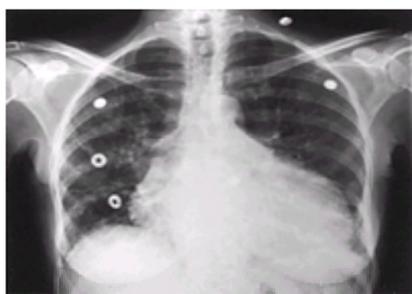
Chest roentgenogram demonstrates a large pericardial effusion, blunting of the left costophrenic angle, and patchy pulmonary infiltrates in a patient with systemic lupus erythematosus.
